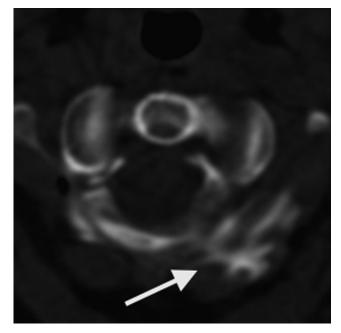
Postepidural blood patch administration axial CT image with extravasated contrast in the surrounding paraspinous soft tissues (arrow).
